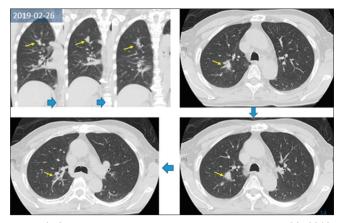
Chest computed tomography scan from February 26, 2019, favored primary lung cancer due to the lesion's location in the upper lung (where blood supply is less rich than in the lower lung) with spiculated border, contrast enhancement, presence of air bronchogram, punctate calcification, and bronchovascular invasion (arrow)
